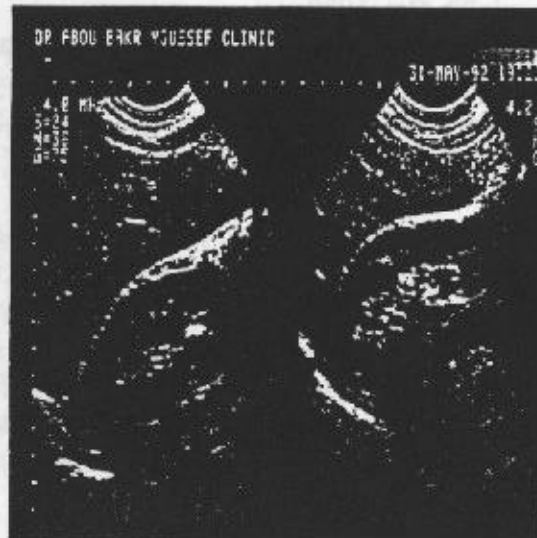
(c) Cirrhotic B-mode ultrasound image
